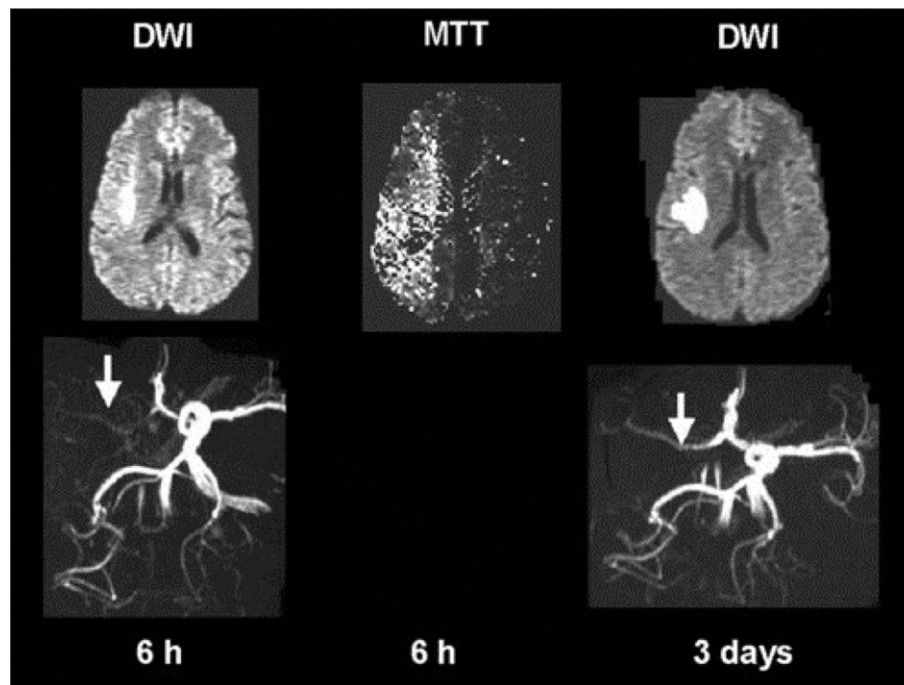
Diffusion weighted imaging (DWI) sequence 6 h after the onset of a stroke showing a circumscribed area of high signal indicating disturbed diffusion. This represents infarction of the brain. The magnetic resonance (MR) angiography after 6 h shows absent flow in the right middle cerebral and carotid artery. The mean transit time (MTT) MR shows hypoperfusion of the total right middle cerebral artery territory. The area of hypoperfusion on the MTT MR minus the area of disturbed diffusion on the DWI MR is generally considered to be the penumbra. The DWI MR after 3 days shows that the hypoperfused area has not progressed to infarction. The MR angiography shows reperfusion of the right middle cerebral artery through the circle of Willis. Courtesy of Geoffrey Donnan, National Stroke Research Institute.
